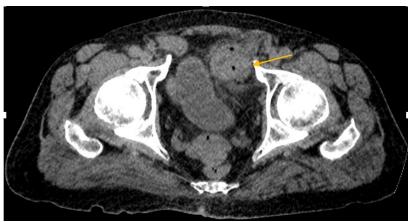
Abdominal CT scan revealing herniated intestinal loops in a sac-like arrangement (arrow) in the prebladder space, compressing the anterior wall of the bladder
